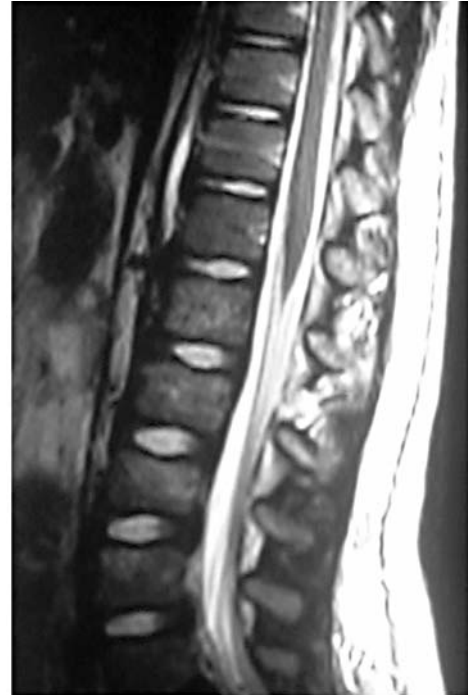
Magnetic resonance imaging (MRI): on T2-weighted fat-saturated sequences, there is a hyperintensity signal alteration of the posterior ligamentous elements, evocative of a lesion of these structures
